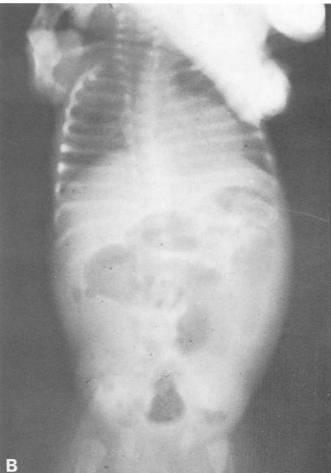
Incarcerated right inguinal hernia in a 5-week-old boy. B. Abdominal roentgenogram shows abnormal dilated intestinal loops and air in the inguinal canal. C. Ecchymotic area of small intestine that was incarcerated in the hernia. Fortunately, the intestine was viable and resection was not necessary. Reprinted with permission of publisher [1].
